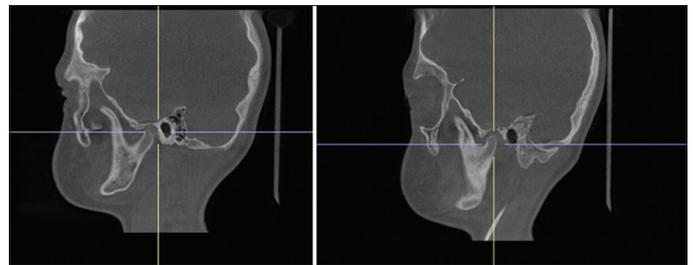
Left and right sagittal computed tomography scans for the second patient showing coronoid hyperplasia
